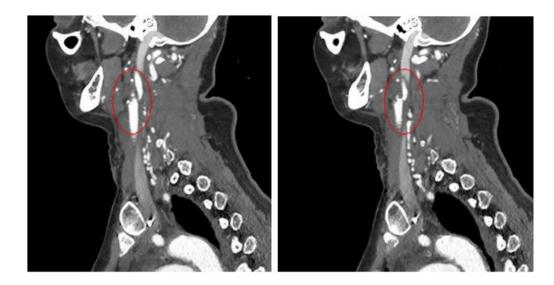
Computed tomography of brachiocephalic arteries in the angiographic mode after transfer from a gynecological hospital: alterations in the zone of bifurcation of the carotid artery interpreted as parietal thrombosis (the zone of the expected thrombosis is isolated).
